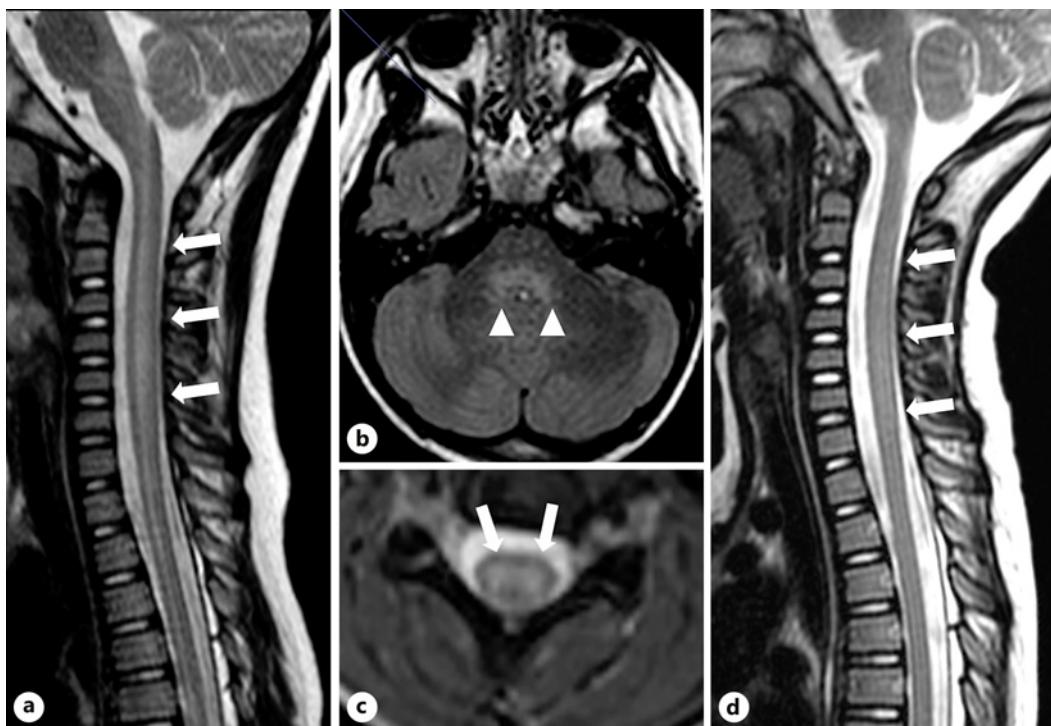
MRI findings at admission (a–c) and follow-up (d). a Sagittal T2-weighted image shows longitudinally extensive increased signal intensity and moderate swelling of the cervical spinal cord (arrows). b Axial T2 FLAIR-weighted image shows increased signal intensity of the dorsal pons (arrowheads). c Axial gradient-recalled echo (GRE) T2-weighted image at the level of C4 demonstrates ill-defined increased signal intensity of entire central gray matter with sparing of peripheral white matter (arrows). d MRI of the spinal cord after 4 days treatment shows near-complete regression of signal abnormalities (arrows).
